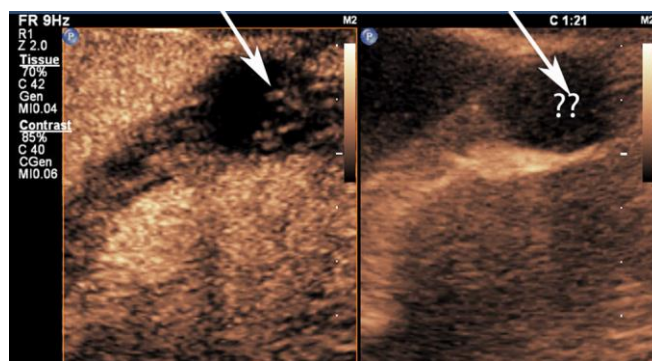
Echogenic cyst on right kidney of the same patient (a). Contrast-enhanced ultrasound in echogenic cyst: perfused solid part: Bosniak IV: Renal cell carcinoma (arrows) (b).
